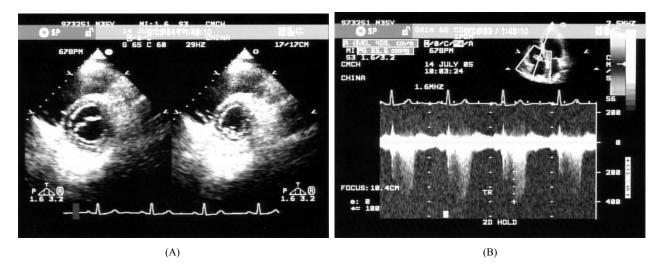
The follow-up echocardiography revealing the progression of the pulmonary arterial hypertension (pulmonary artery pressure: 75 mmHg)
